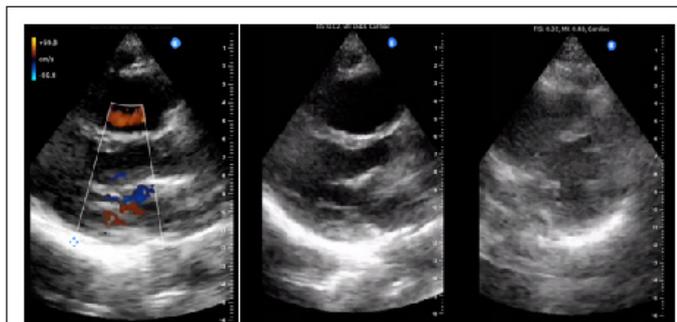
Various intraoperative parasternal transthoracic echo images throughout her resuscitation
